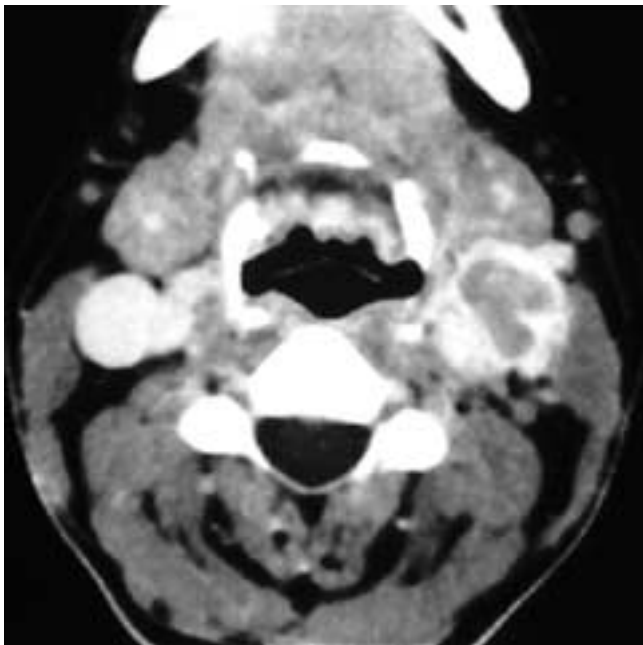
Axial contrast-enhanced CT scan shows a necrotic left level II node with a thick, nodular, enhancing rim. The enhancement extends into the adjacent soft tissues, indicating extracapsular tumor spread. This extranodal disease is adjacent to the carotid artery, suggesting invasion of the arterial wall.
